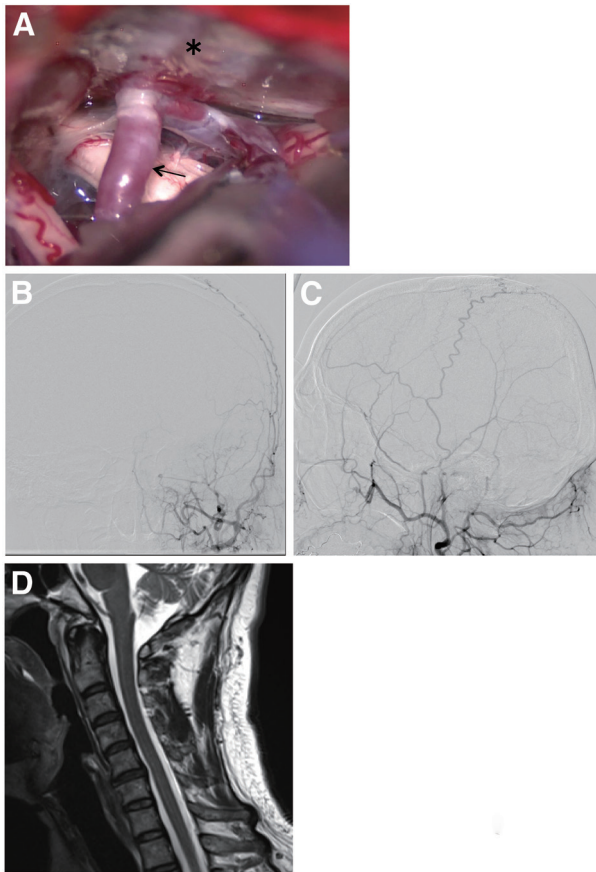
(A) An intraoperative photograph shows an arterIALIZED petrosal vein (black arrow) hanging from the lateral inferior side of the tentorium (asterisk). (B, C) Anterior–posterior view and lateral view in the left external carotid angiography show the complete occlusion of the tentorial dural arteriovenous fistula. (D) The sagittal section of the postoperative MRI shows that the T2-hyperintensity and the swelling in the brainstem and spinal cord have disappeared. The perimedullary vascular flow voids completely disappeared.
